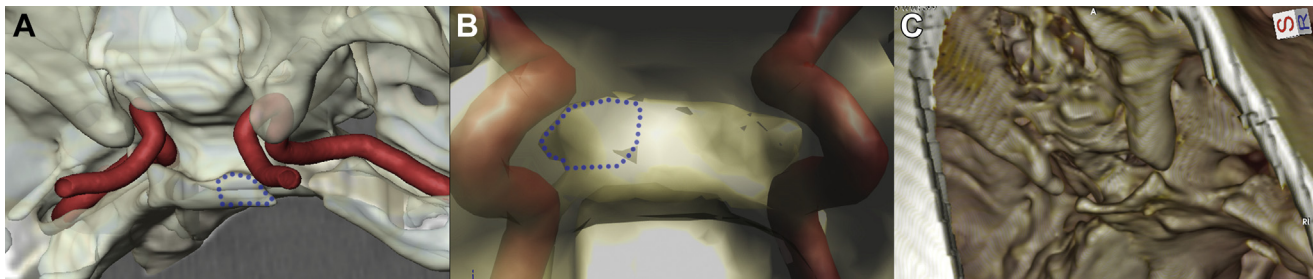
(A and B) Bone anatomy of the anterior skull base using an interface designed through specific imaging software for the manipulation of biomedical data. This system allows the neurosurgeon to perform a step-by-step virtual dissection and to precisely tailor the extent of the posterior clinoidectomy in a virtual three-dimensional environment. (C) A preliminary analysis of the predissection computed tomography scan was performed using open-source software for navigating in multidimensional Digital Imaging and Communications in Medicine images to meaningfully evaluate the three-dimensional perspective of the individual anatomic variability.
